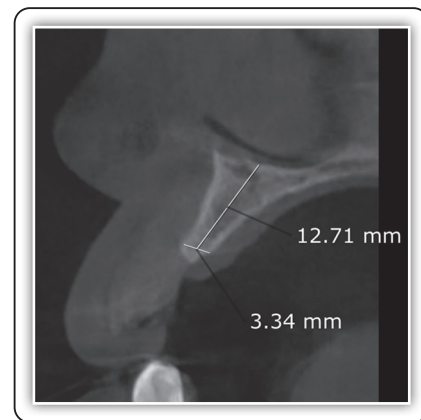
Cone beam CT showing a horizontal bone width of 3.34 mm and vertical bone height of 12.71 mm in the maxillary right lateral incisor region
